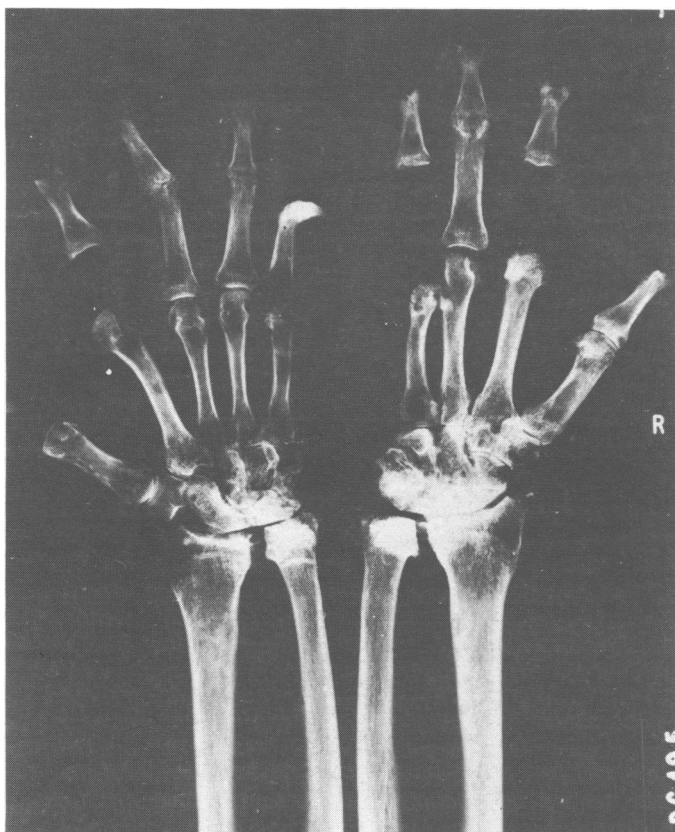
Radiograph of a woman with rheumatoid erosions of the carpus and metacarpal heads.
